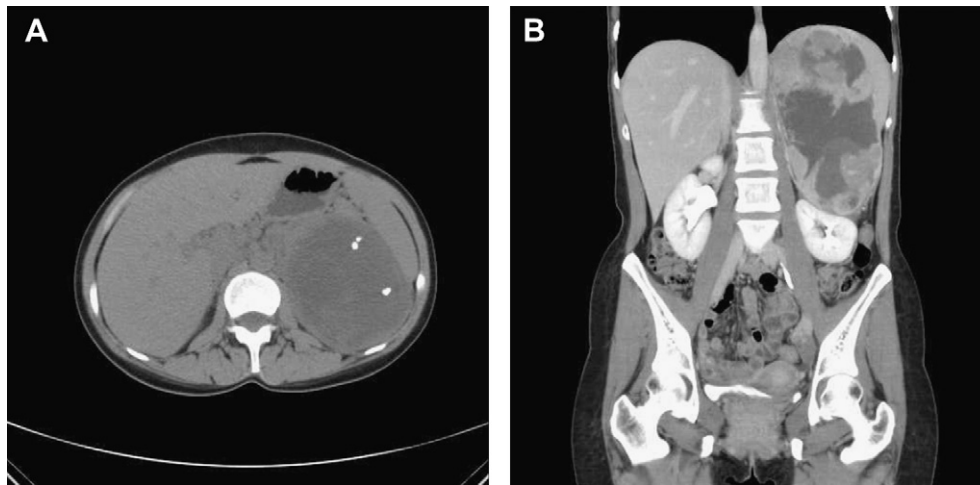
(A) Noncontrast unenhanced computed tomographic (CT) scan revealing a well-defined huge mass with severe necrosis and evident calcifications. (B) Contrast-enhanced CT, showing a delayed attenuation of approximately 56–78 HU (on an approximately 10–15-minute delayed enhanced CT).
